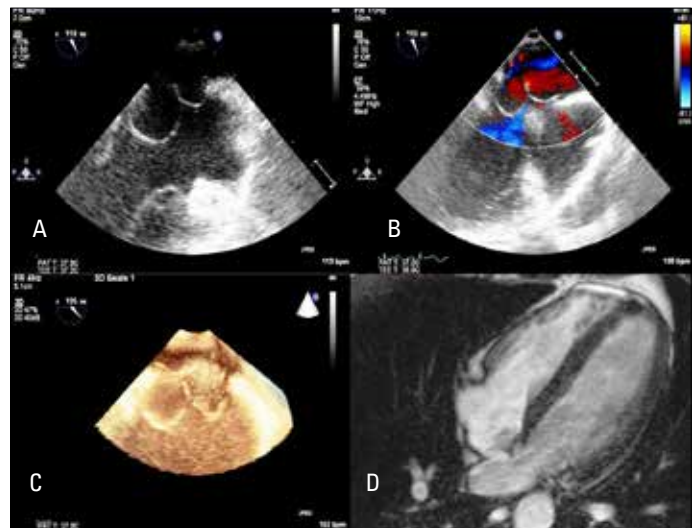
A, B) TEE image from 120 degree mid-esophageal level shows an accordion like IASA and transition from small atrial septal defect by color Doppler. IASA-interatrial septal aneurysm, C) 3D RTEE shows accordion like IASA, D) Vertical long-axis view of cardiac MRI showed IASA and small atrial septal defect.
